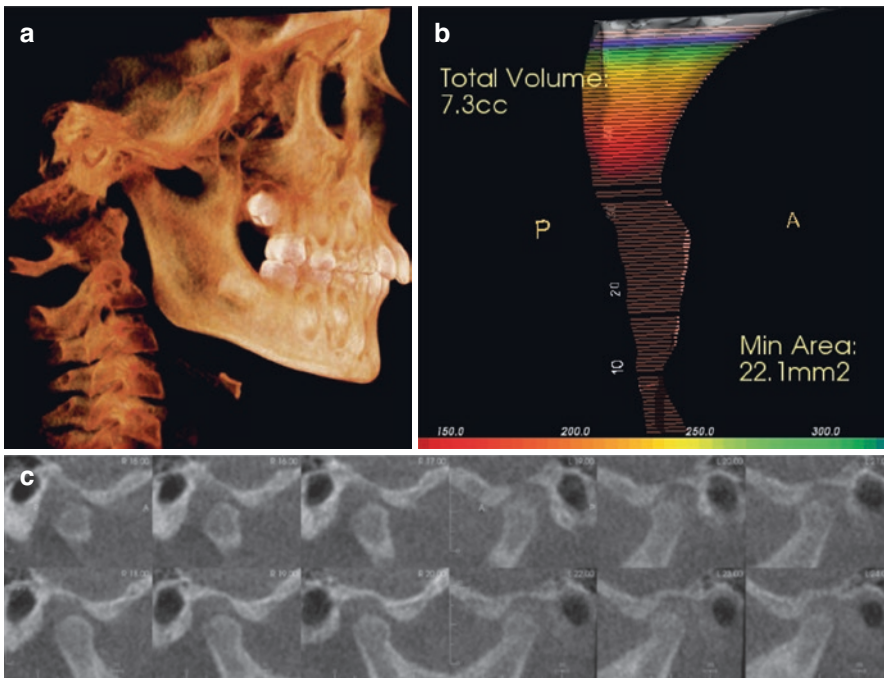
(a) CBCT 3D lateral reformation shows the teeth of this patient in maximum intercuspation during imaging. (b) The airway dimensions are small; (c) in maximum intercuspation, the condyles are not seated in the fossae and are positioned inferiorly and anteriorly as one would expect in a forward mandibular posture. The mandible was most likely postured forward chronically to breathe, and the posterior teeth supererupted creating a dual bite. If the condyles seat in the fossae, the bite will open up anteriorly. This is not an orthopedically stable occlusion
